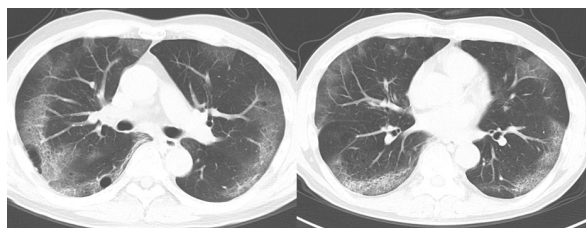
Chest CT images of COVID-19. Chest CT images at 14 days after symptom onset showed peripheral ground glass opacity with crazy-paving appearance in both lungs, which were typical findings of COVID-19 pneumonia.
